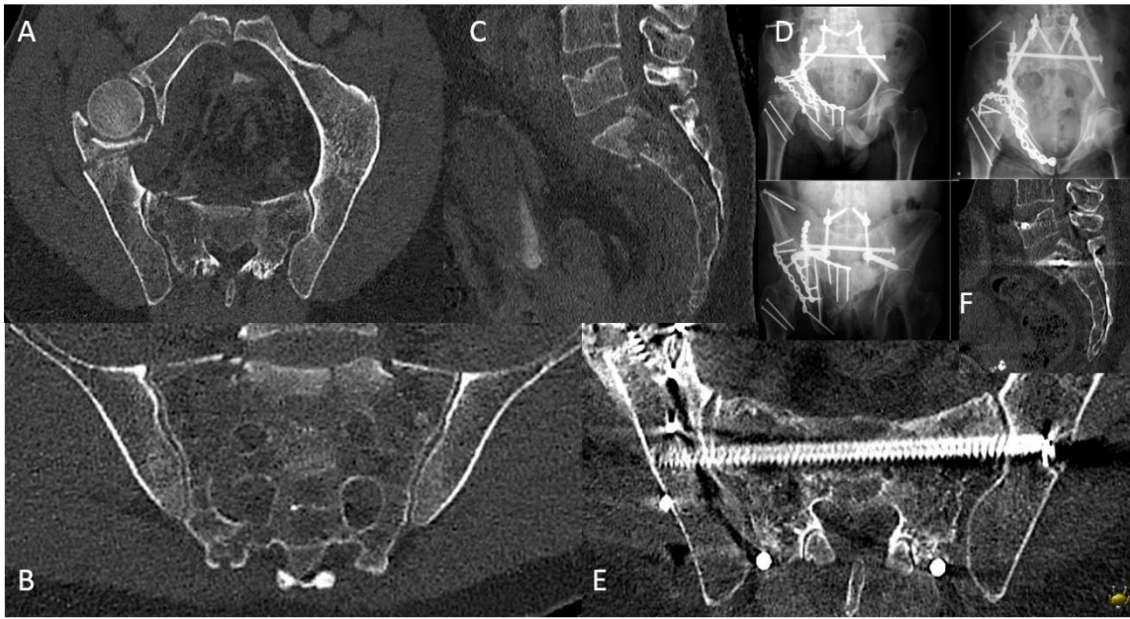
Patient suffering from a T-Type spinopelvic dissociation with comminuted acetabular fracture: A-C) fracture pattern, D) immediate postoperative X-ray, E-F) 1 year follow-up
